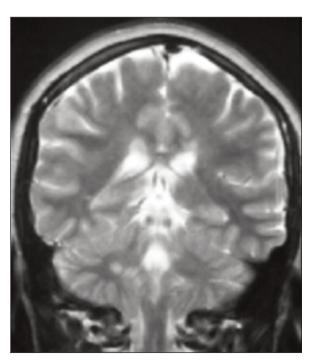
Coronal T2-weighted MR image shows two hyperintens foci in the right middle cerebellar peduncle in addition to the lesion locating in the right periventricular white matter.
